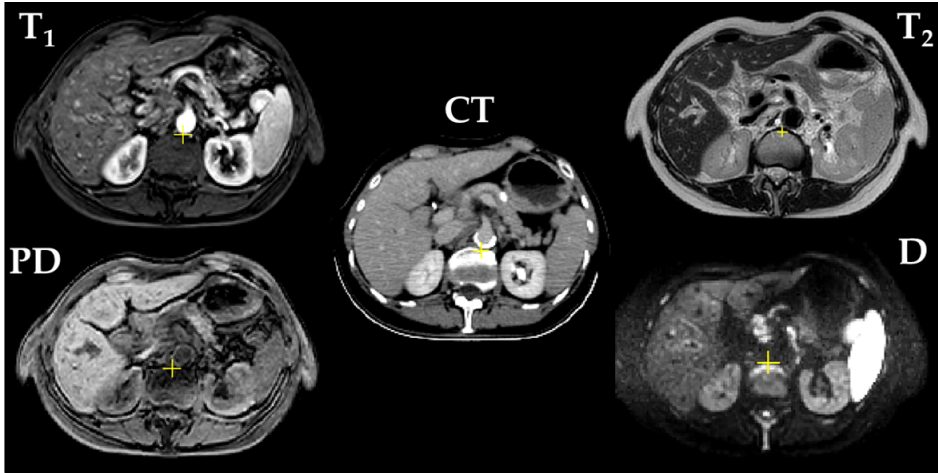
Versatility of MR image contrast in comparison with CT in a patient with pancreas cancer. Sequential MRI scans that encode different tissue properties into the image, while CT only encodes the relative electron density. The MR derived tissue properties shown are longitudinal relaxation (T_1), transverse relaxation (T_2), proton density (PD) and the diffusivity (D). Note that both the CT scan and the T_1 scan are acquired with administration of contrast agent.
